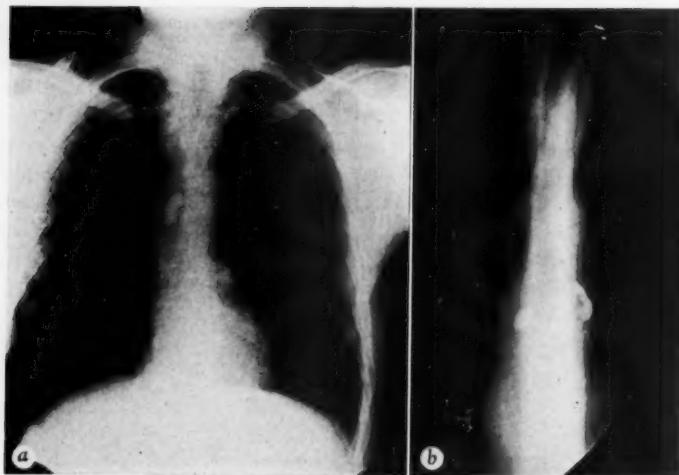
Roentgenogram shows evidence of a large area of calcification along the right side of mediastinum in hilar area. b. Tomogram showing areas of calcification in course of both the left and right stem bronchi.
